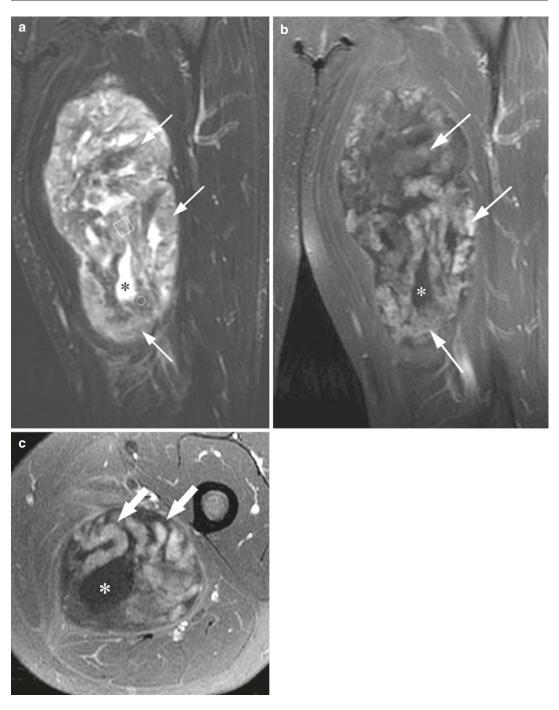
(a–c) Low-grade fibromyxoid sarcoma in the thigh of a 59-year-old man. (a) Coronal T2-weighted fatsaturated image shows gyriform pattern (*arrows*) of heterogeneous T2 signal intensity. The gyriform pattern consists of hypo-, iso-, and hyperintense signal and probably reflects alternating areas of densely fibrotic (*circle*) and fibromyxoid (*square*) stroma of tumor. The fluid-like high-signal area (*asterisk*) probably represents predominantly myxoid area in the tumor. (b) Coronal and c axial T1-weighted fat-saturated post-contrast images show gyriform contrast enhancement (*arrows*). The myxoid component (*asterisk*) lacks contrast enhancement (Reprinted with permission from Hwang et al. [62])
